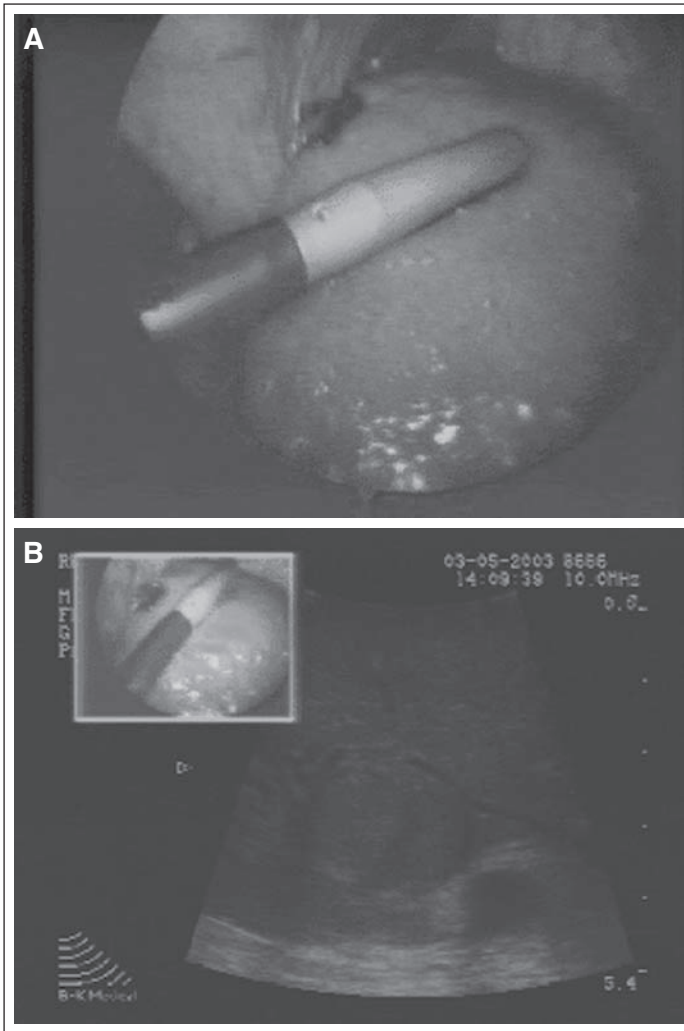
Laparoscopic probe (Aloka) above liver (A) and the associated ultrasound view (B). Images courtesy of Shea Gregg, M.D., Yale University and David Tannitti, M.D., Brown University.
